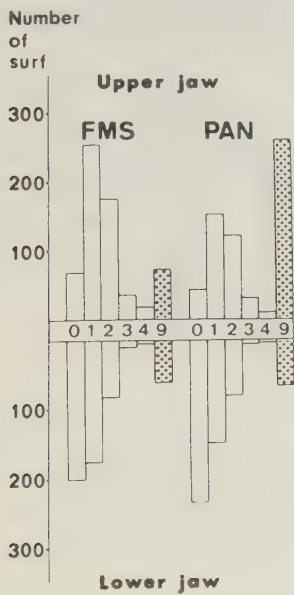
The distribution of differerent bone score units (value 0-4) on mesial and distal surfaces for the posterior regions in full mouth surveys and orthopantomographs.
